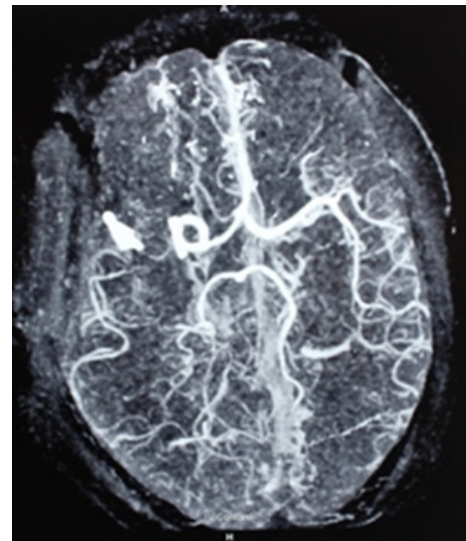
Post operative CT angiography demonstrated disappearance of the aneurysm and patency of high flow bypass in the saphenous vein graft.
